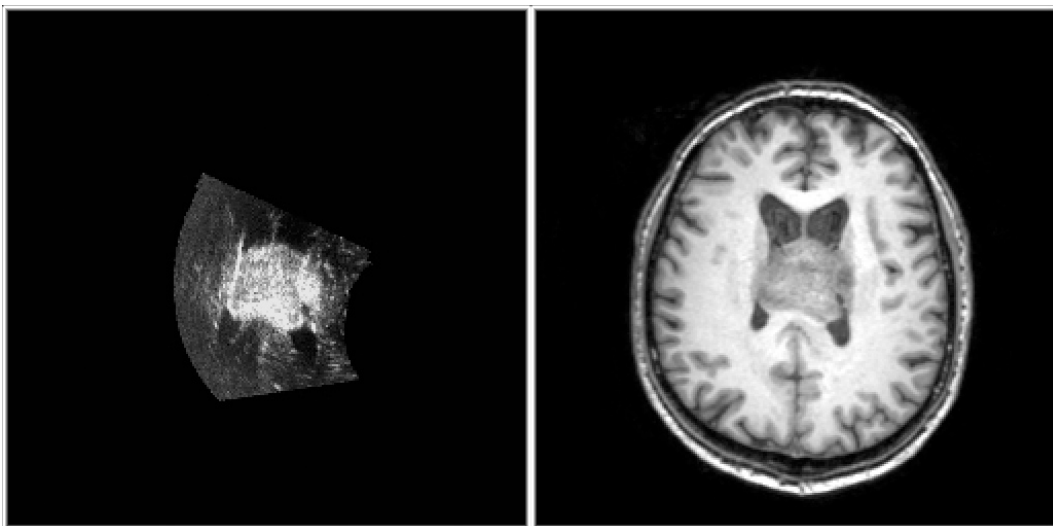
Corresponding slices from US and MRI volumes of the same patient. Left is a slice from the resampled volume of the compounded freehand ultrasound scan. Right, the same T1 weighted MRI as in figure 2.
